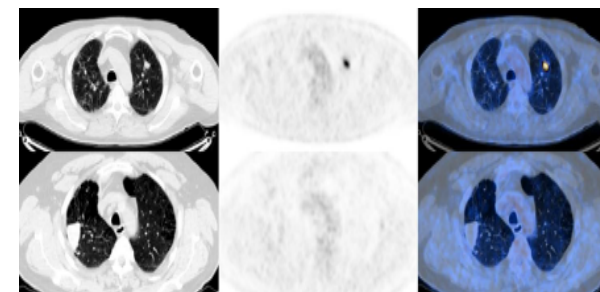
PET/CT study with $^{18\text{F}}$ -FDG – transverse slices. A. Left-lung tumour with increased $^{18\text{F}}$ -FDG accumulation – high probability of malignancy. B. Right-lung tumour with normal $^{18\text{F}}$ -FDG accumulation – low probability of malignancy. Courtesy of PET/CT Center Starmedica, Szczecin
